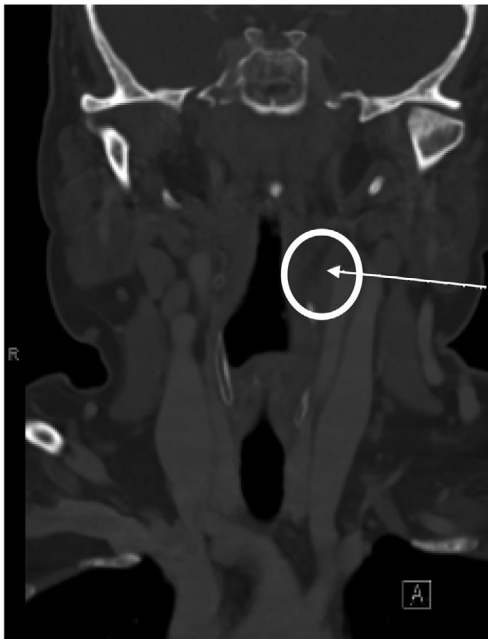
TIPIC syndrome on the coronal plane of the CTA neck. Arrow identifies evidence of circumferential thickening of the left carotid bulb. Abbreviations: CTA, computed tomography angiography; TIPIC, transient perivascular inflammation of the carotid artery.
